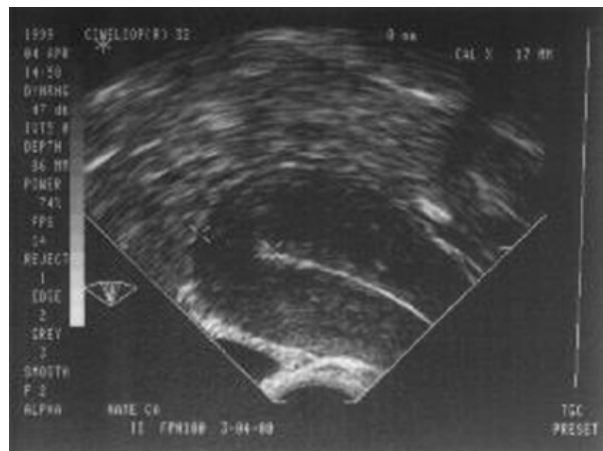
Transvaginal ultrasound scan of the FibroPlant-LNG IUS *in situ*.
